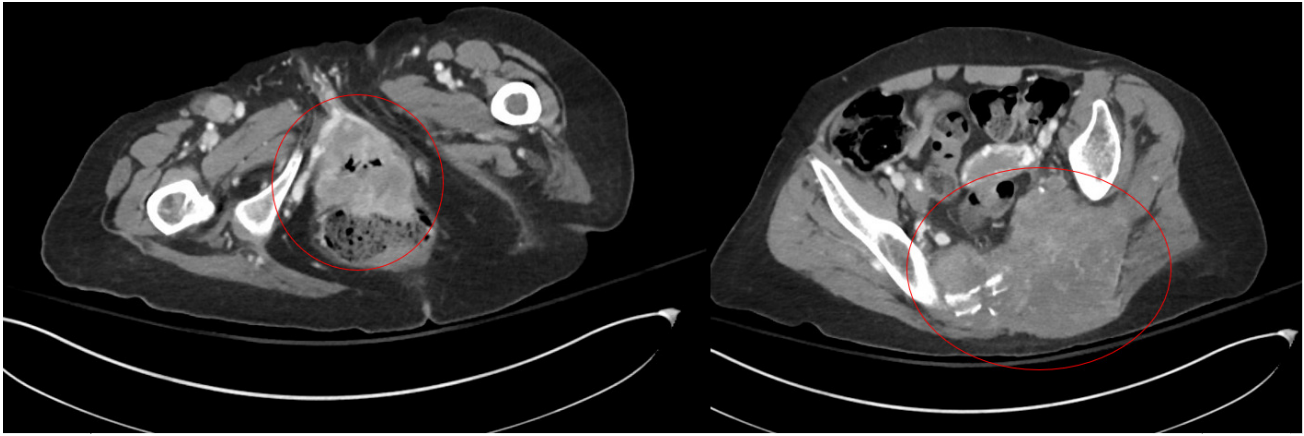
CT chest/abdomen/pelvis with and without contrast. Axial plane images with a red circle showing large circumferential soft tissue mass extending to perineal soft tissues, vaginal cuff, and left gluteal fold (left panel). Large destructive soft tissue mass with significant osseous destruction of the sacrum and coccyx (right panel).
